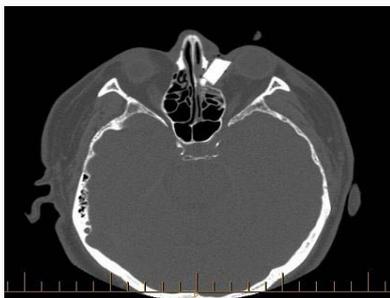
Left sided foreign body identified on CT scan.
